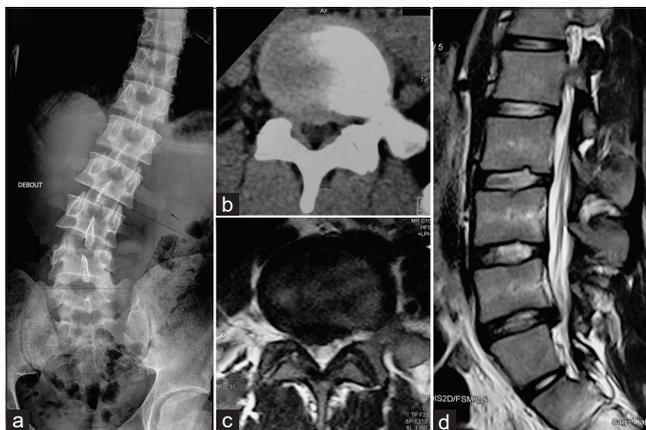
Anteroposterior plain radiograph of the thoracolumbar spine showing a primary right lumbar curve (Cobb angle 30° and 70 mm deviation) without rotational spinal deformity (a), axial lumbar spinal computed tomography scan (b), axial (c), and sagittal T2-weighted images (d) demonstrating a right paramedian lumbar disc herniation at L4–L5 level.
